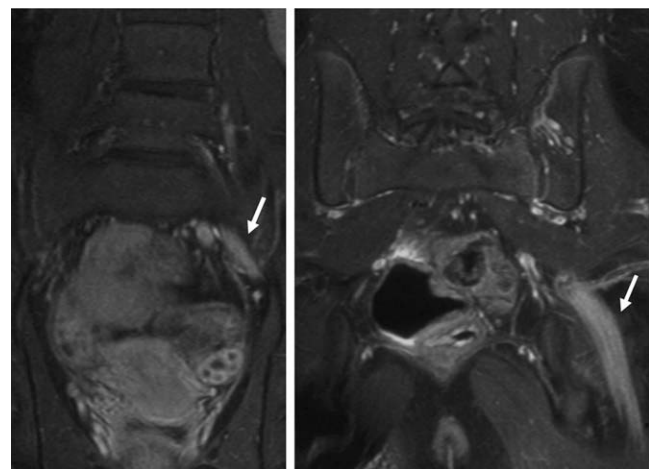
MRI. Gadolinium-enhanced T1-weighted images. The left lumbosacral enlarged nerve root is enhanced by gadolinium (white arrows).
